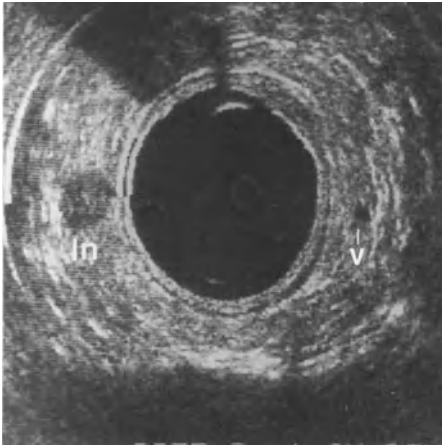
Sonogram proximal to a rectal cancer. Due to the non-specific inflammation caused by tumour destruction of the mucosa a hyperechoic lymph node (*ln*: size 6 mm) is visible on the left side of the sonogram
